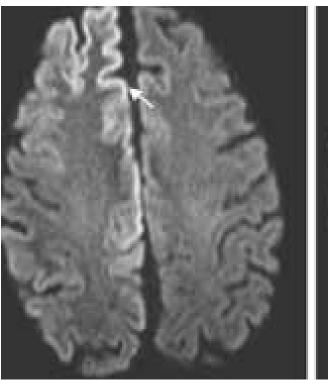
DWI/ADC view showed the area of restricted diffusion symmetrically in bilateral basal ganglia including caudate and lentiform nuclei and cortical ribbon sign which is an increased signal delineating the cortex.
